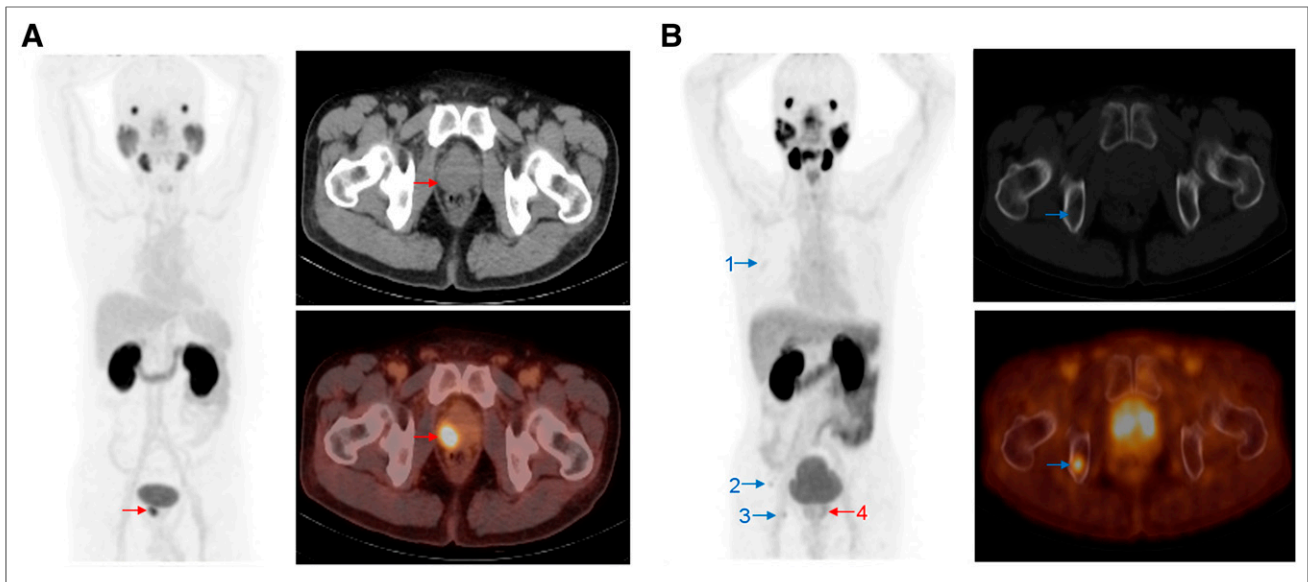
Maximum-intensity projections (left), CT images (top right), and PET/CT images (bottom right) of 2 patients at 1 h after injection. (A) In 63-y-old man with prostate-specific antigen level of 12.6 ng/mL and Gleason score of 3 + 3 = 6, CT and PET/CT images show primary tumor (SUV_{max}, 16.85). (B) In 62-y-old man with prostate-specific antigen level of 20 ng/mL and Gleason score of 3 + 3 = 6, CT and PET/CT images show 1 bone metastasis (metastasis 3: SUV_{max}, 4.37). Red arrows indicate primary tumors, and blue arrows indicate bone metastases.
